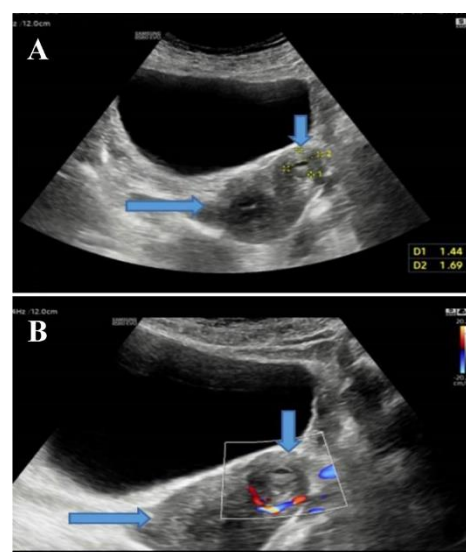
A 32-year-old multiparous presenting with recurrent left lower abdominal pain. (A) Axial grayscale image and (B) color Doppler image show the uterus (horizontal arrow) and ACUM (vertical arrow) with peripheral vascular flow in the left lateral wall of the uterus
